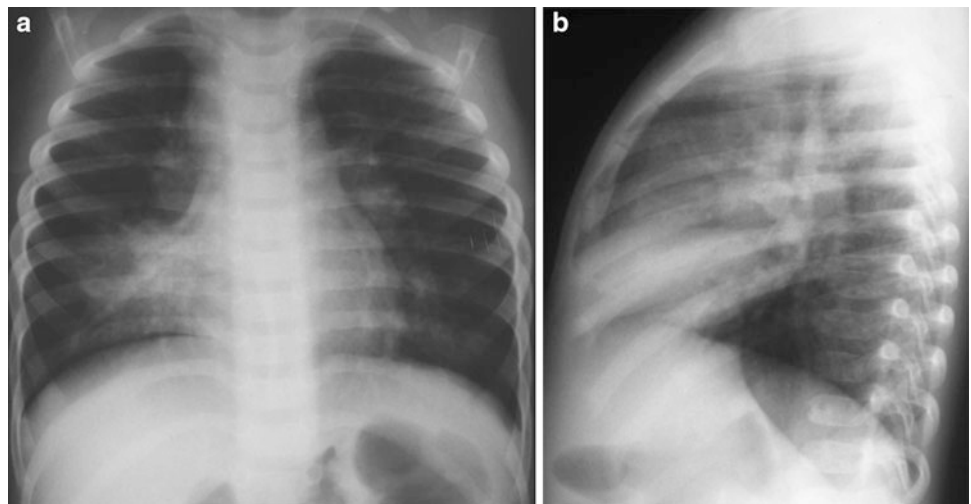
a Frontal view Chest X-ray of a 7-year-old girl with positive tuberculin skin test shows a prominent right perihilar shadow compatible with lymphadenopathy. No appreciable lung parenchymal abnormality is seen. b Lateral view confirms the lymphadenopathy superimposed on the mediastinal vessels
